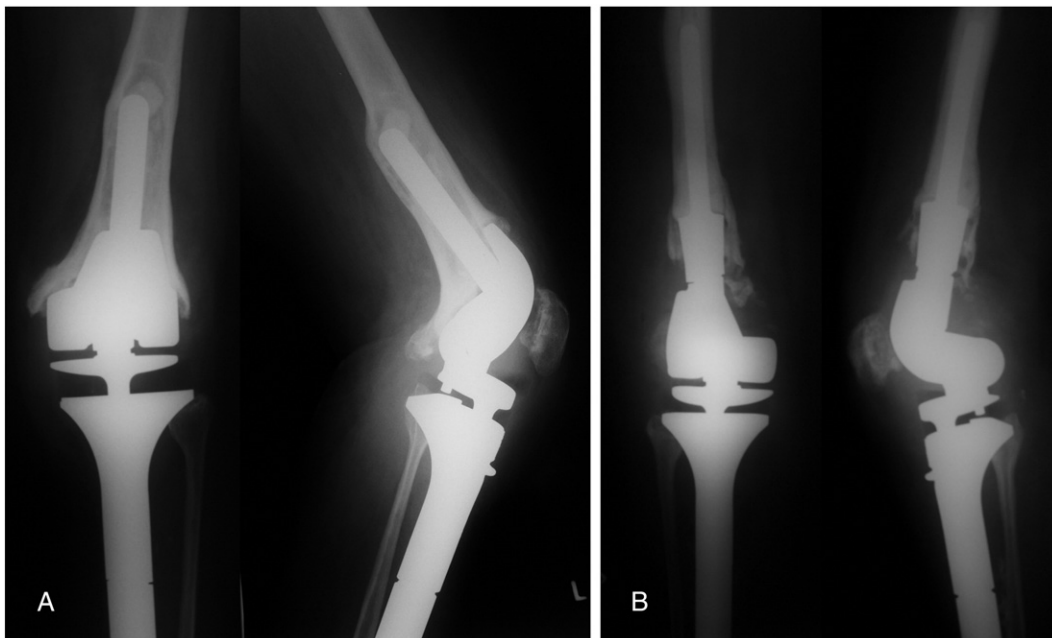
(A) Radiographs of the left knee in anteroposterior and lateral views show knee prosthesis femoral stem loosening with varus and posterior drift and femur posterior cortex remodeling and thickening. (B) Radiographs of the left knee in anteroposterior and lateral views show satisfactory rotating hinge total knee megaprosthesis and allografts.
